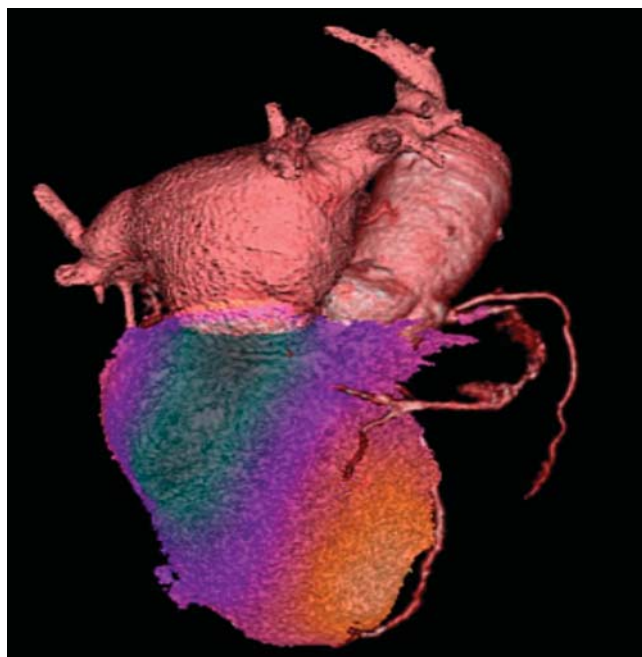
Co-Image of the Year. This hardware-fused imaged reveals the incremental value in fusing information from SPECT and CT angiography in the setting of coronary artery disease.
